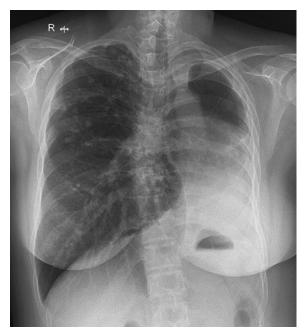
Chest Radiograph (2023). Inactive tuberculosis with destroyed left lung.
